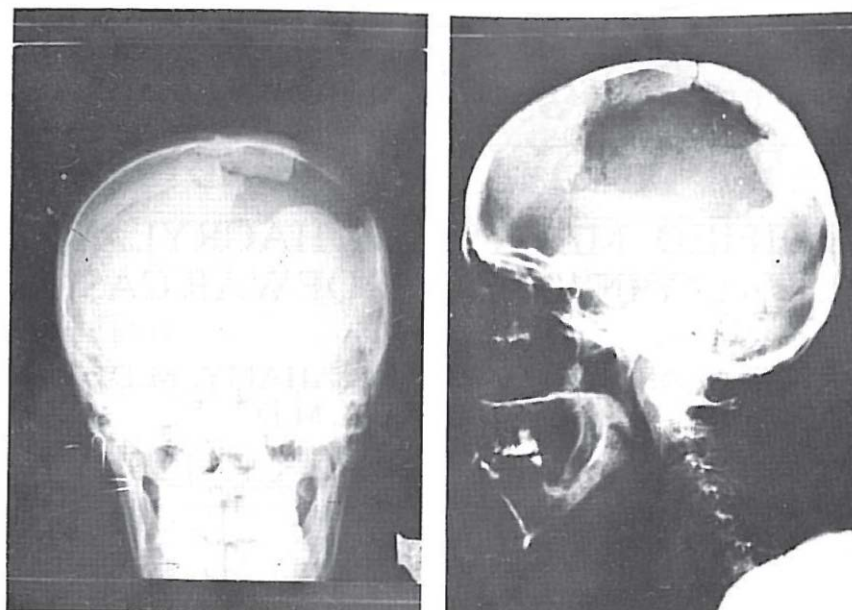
Radiography of skull bone defect in war casualty.
